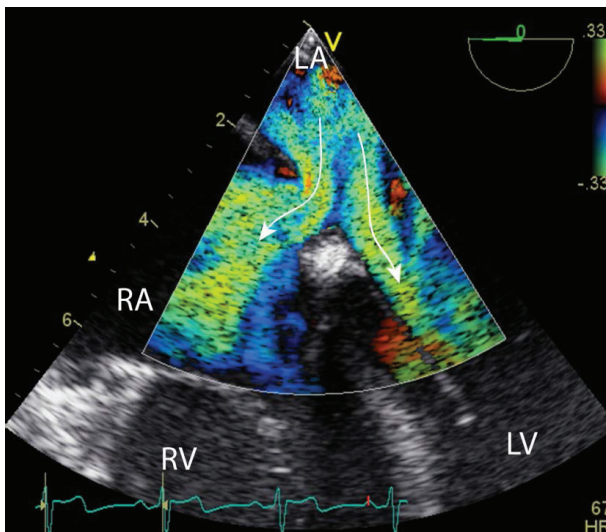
Transesophageal long-axis-view of the atrial septum: Blood Flow Imaging in the visualization of two atrial septal defects (ASD), the left atrium (LA) and the right atrium (RA). The arrows show the direction of the speckle pattern.
